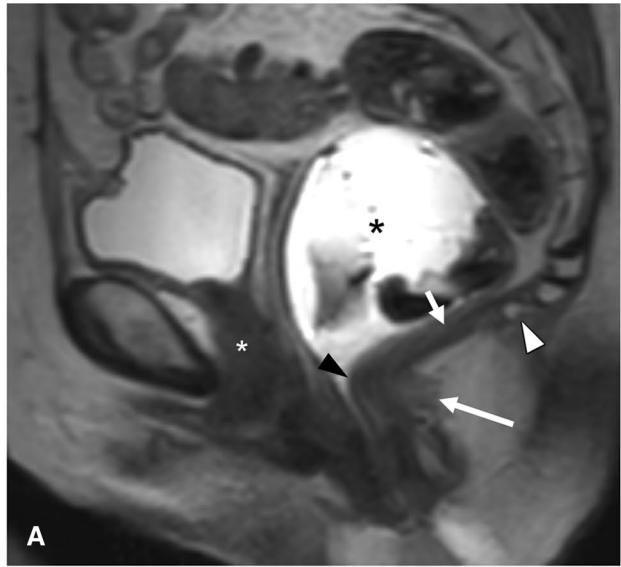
Normal pelvic support structures. a Sagittal T2-weighted image demonstrates posterior aspect of puborectalis (long arrow) seen at the level of anorectal junction (black arrowhead). Levator plate (short arrow) extends from the coccyx (white arrowhead) to the anorectal junction. Note normal vertical location of the urethra (white asterisk) and hyperintense gel distending the rectum (black asterisk). b Axial T2-weighted image demonstrates the sling of puborectalis (long arrow) attaching to the pubis (short arrow) and wrapping around the anorectal junction (*). c Axial T2-weighted image superior to (b) demonstrates pubococcygeus (long arrow) coursing from the pubis (*) to the levator plate (short arrow). d Axial T2-weighted image superior to (c) demonstrates iliococcygeus fibers (arrows) extending from the obturator fascia to the coccyx (short arrow)
